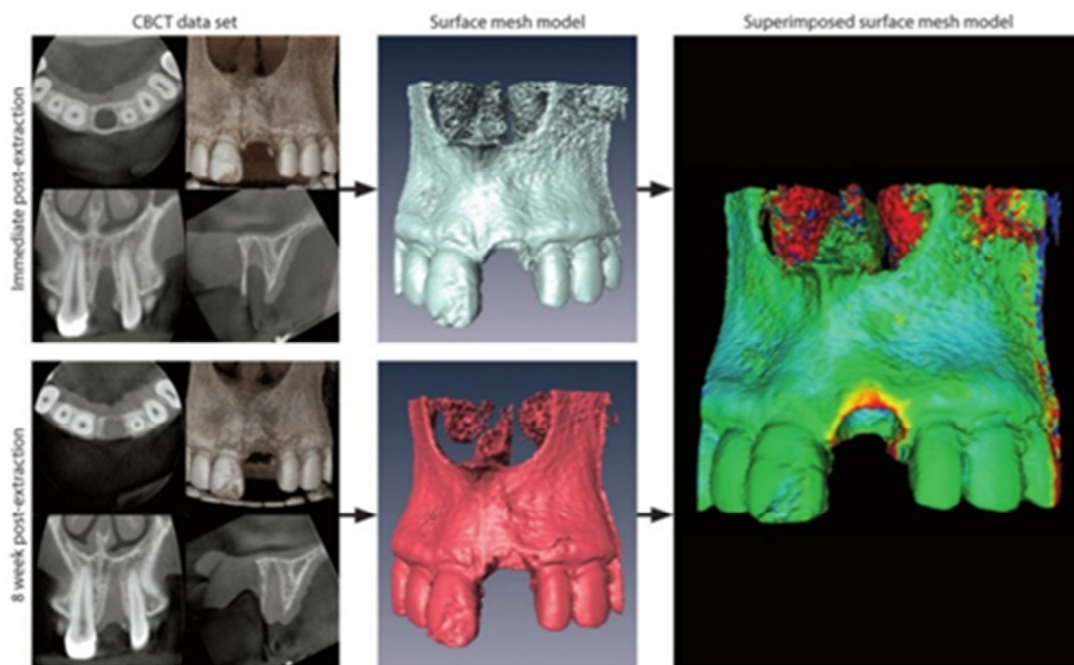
SUPERIMPOSITION OF 3D MODELS FROM CBCT AND COLOR CODE VOLUME DIFFERENCE (IMAGE TAKEN FROM THE ARTICLE OF CHAPPUIS 2013)
